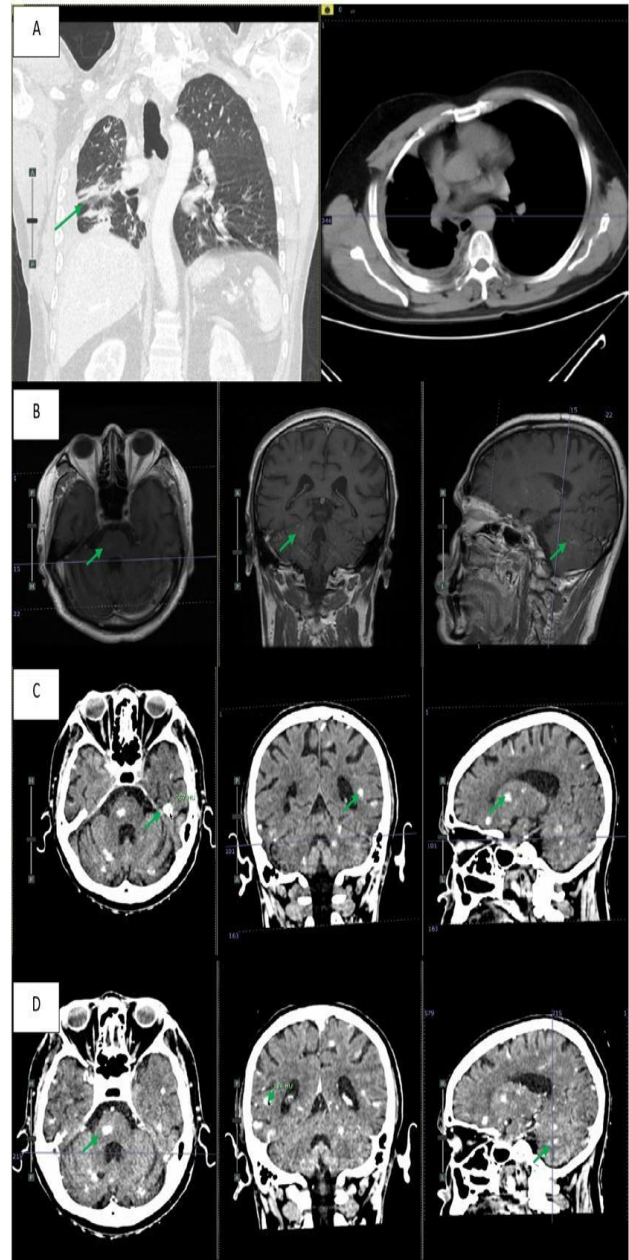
Lung and Brain Imaging (A) Contrast-enhanced thoracic CT scan showing an irregular lesion in the right middle lobe. (B) Contrast-enhanced brain MRI, T1-weighted sequence, revealing numerous hyperintense lesions in the brain parenchyma and bilateral cerebellum. (C) Follow-up non-contrast head CT scan demonstrating multiple calcified lesions of varying sizes in the cerebral hemispheres, bilateral cerebellum, and midbrain, suggestive of a metastatic process. (D) Follow-up contrast-enhanced head CT scan showing no contrast enhancement with the same calcified lesions.
